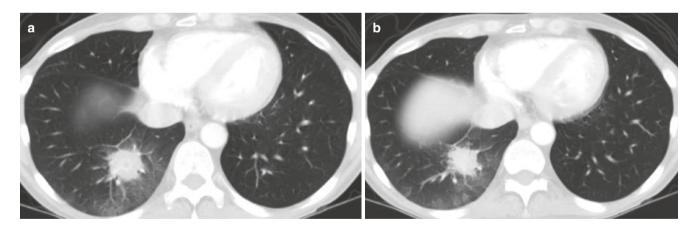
Angioinvasive aspergillosis in a 42-year-old man presenting with neutropenic fever following chemotherapy for acute myeloid leukemia. (a, b) Axial CT images show right lower lobe nodule with "halo" sign
